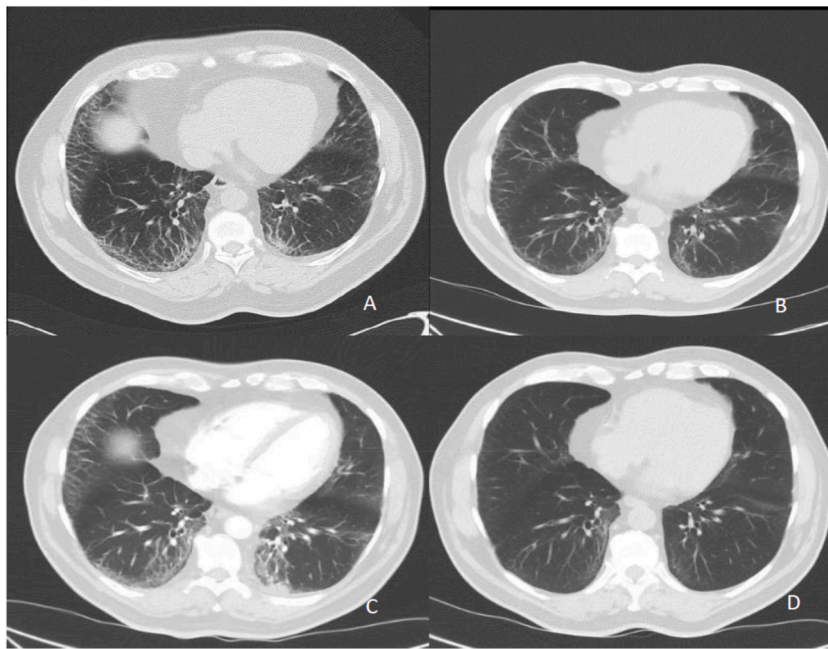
Chest CT evolution
